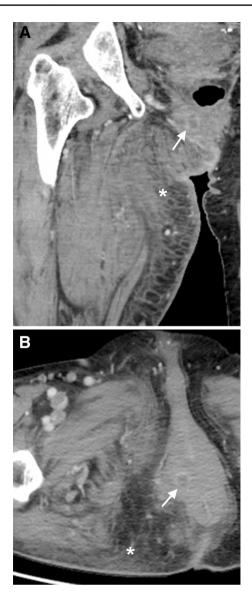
Fournier gangrene secondary to a perianal abscess. a Coronal and b Axial enhanced CT images show a perianal abscess (arrow) with extensive fat stranding and fascial thickening along right perineum, right buttock, and right thigh (*)
